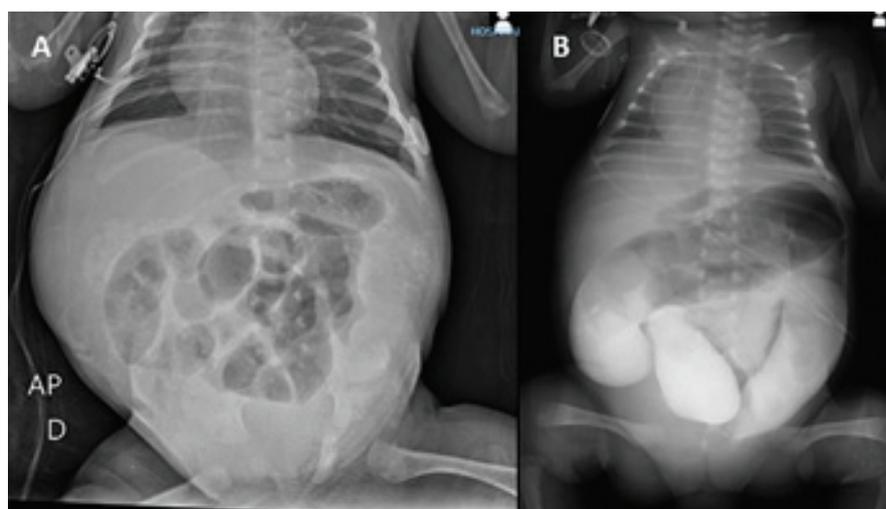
A) Abdominal distension on postnatal abdominal X-ray. B) Opaque enema at 30 days of age showing intestinal distension and obstruction of the intestinal tract.
